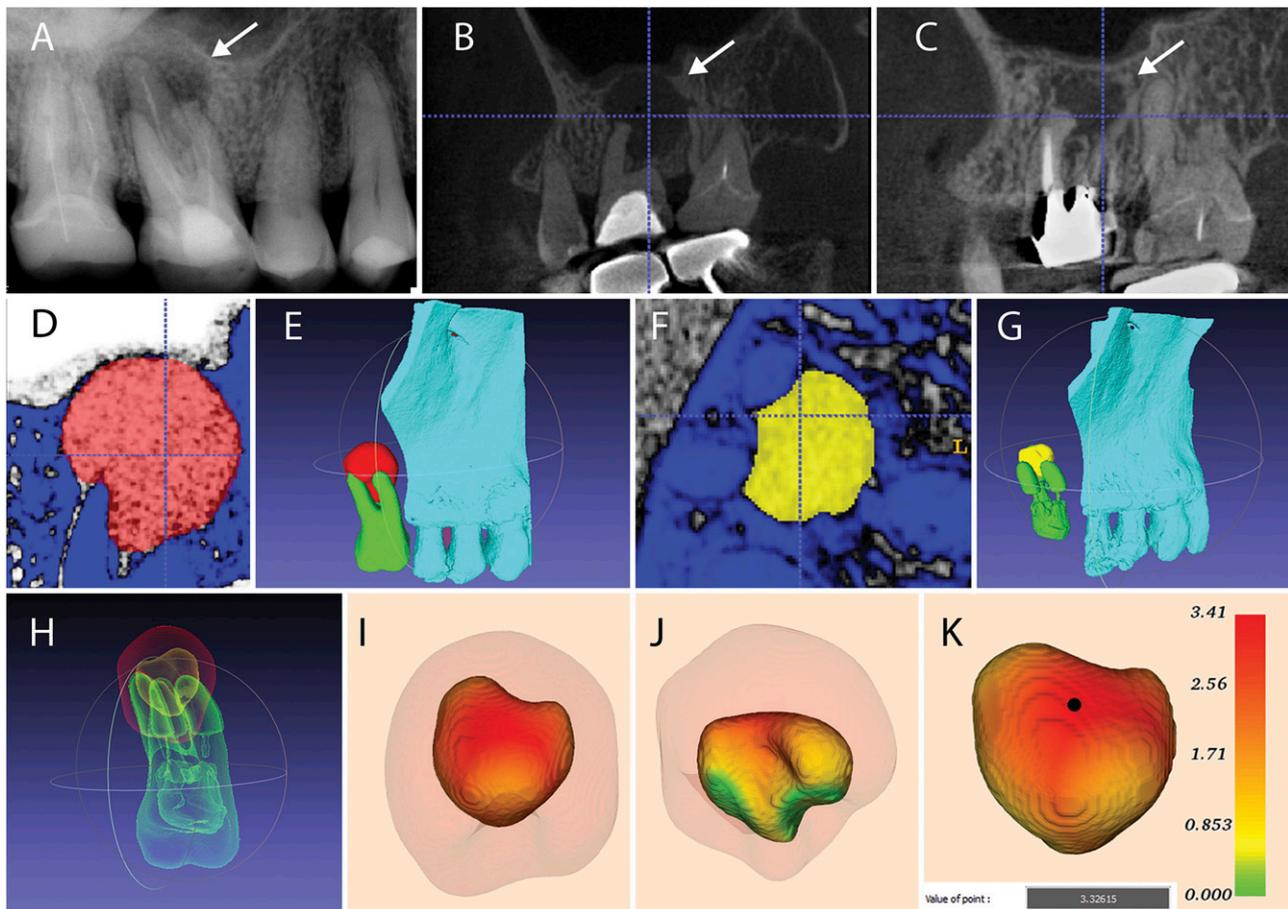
Post-processing of CBCT imaging in Case 1: (a) digital periapical radiography showing the radiolucent image associated with the roots of tooth no. 16 (arrow). (b) A CBCT sagittal slice (T0) demonstrating the periradicular lesion next to the maxillary sinus before the endodontic re-treatment (arrow). (c) A CBCT sagittal slice (T1) demonstrating the periradicular lesion 6 months after the re-treatment (arrow). (d–g) Segmentation, using threshold tool, and construction of virtual three-dimensional (3D) model before the endodontic re-treatment (red label) and 6 months later (yellow label). (h) Virtual 3D models aligned and overlapped. (i, j) Palatal and buccal views of virtual 3D model of periradicular lesion before the re-treatment (translucent) and after re-treatment (colourful). (k) Qualitative and quantitative assessment by colour maps and “point value” tool revealed a greater reduction in the palatal portion of the lesion (3.4 mm).
